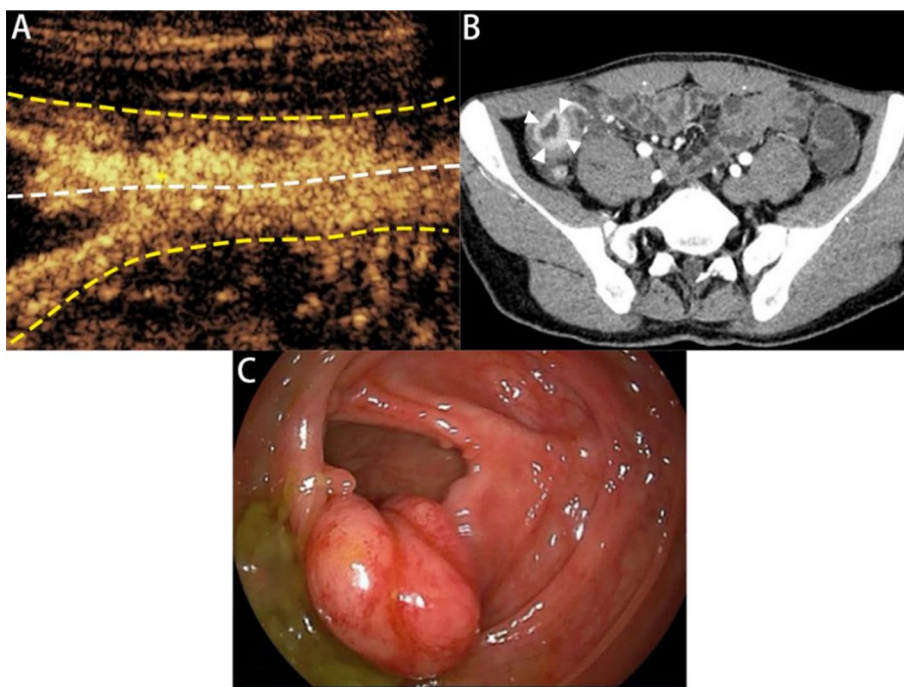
The thickness of the largest thickening of the intestinal wall in active CD. A Longitudinal section of the beginning of the ascending colon at intestinal ultrasound. The BWT is 11.2 mm, and the intestinal wall layer is not clearly stratified (the yellow dotted lines represent the boundary between the serosal layer of the intestinal wall and the surrounding tissue, and the white dotted lines represent the bowel lumen, and the same is applied to the figure legends shown below); B At CTE, the intestinal segment indicated by the triangle is obviously thickened and the intestinal wall layer is not clearly stratified, with BWT about 11.0 mm; C. CD patient with bowel wall thickening on endoscopy. The total SES-CD is 14
